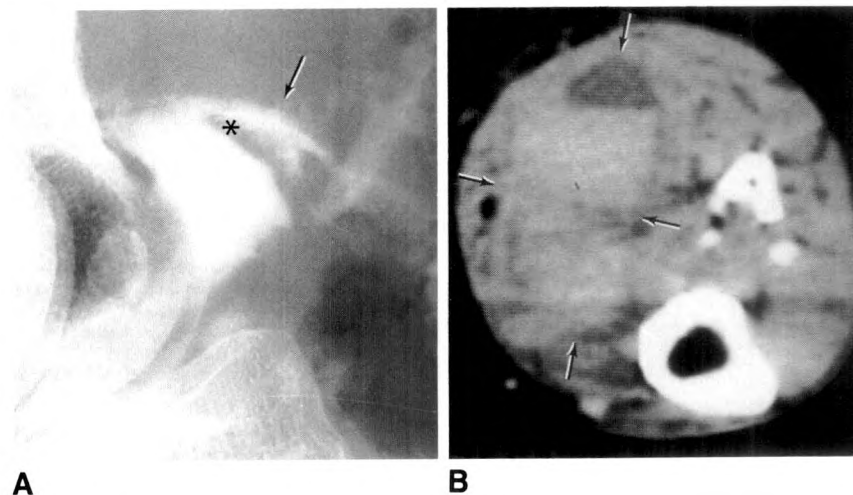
Ruptured popliteal cyst. A, Double-contrast arthrogram shows large popliteal cyst that ruptured into distal calf. Communication between joint and gastrocnemio-semimembranosus bursa (arrow) is well shown. Notice transverse slit (asterisk), which may act as a valve. B, Immediate postarthrography CT scan shows extravasated contrast material and air (arrows) that dissect into gastrocnemius and soleus muscles.
